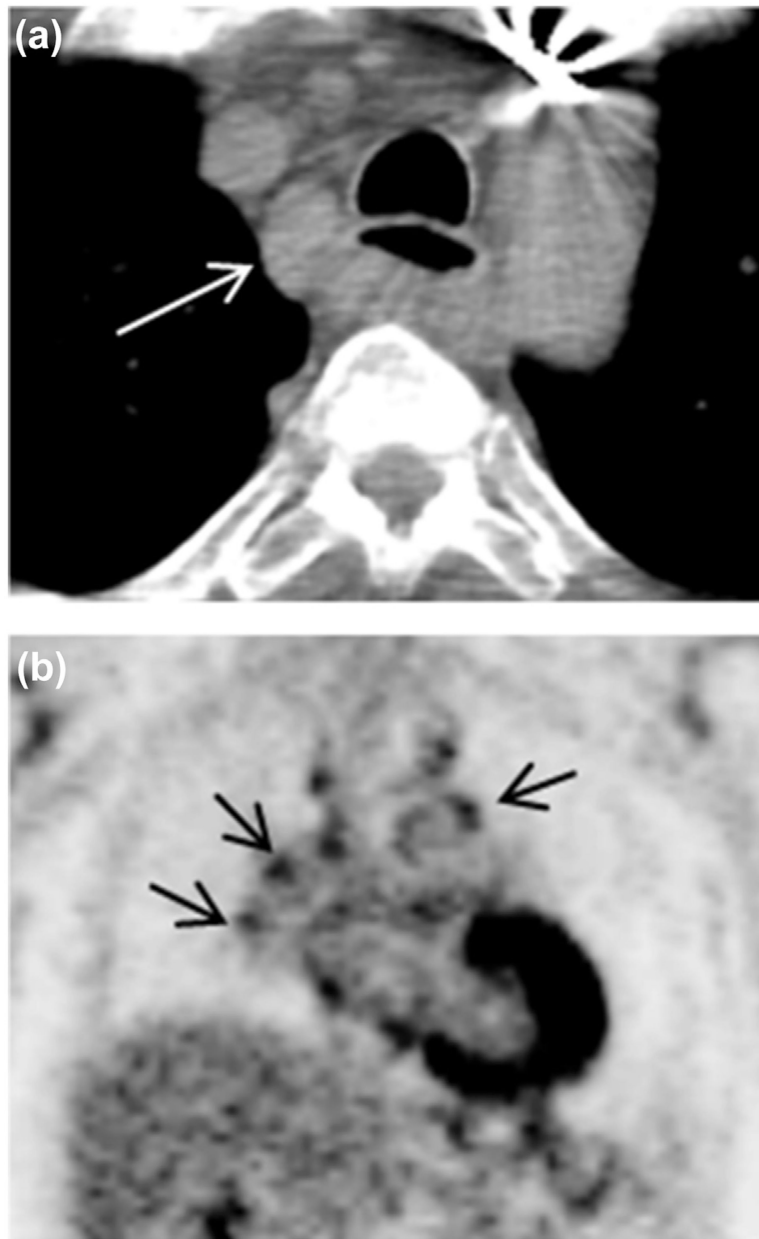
Axial CT image (a) revealed lymph node enlargement on 2R (arrow). Long-axis diameter is 2.38 cm, and short-axis diameter is 1.53 cm. The axial S/L ratio is 0.64. The lymph node had sharpness border. PET coronal image (b) show multiple mediastinal lymph nodes high FDG uptake (arrow). The pathology result is inflammation.
